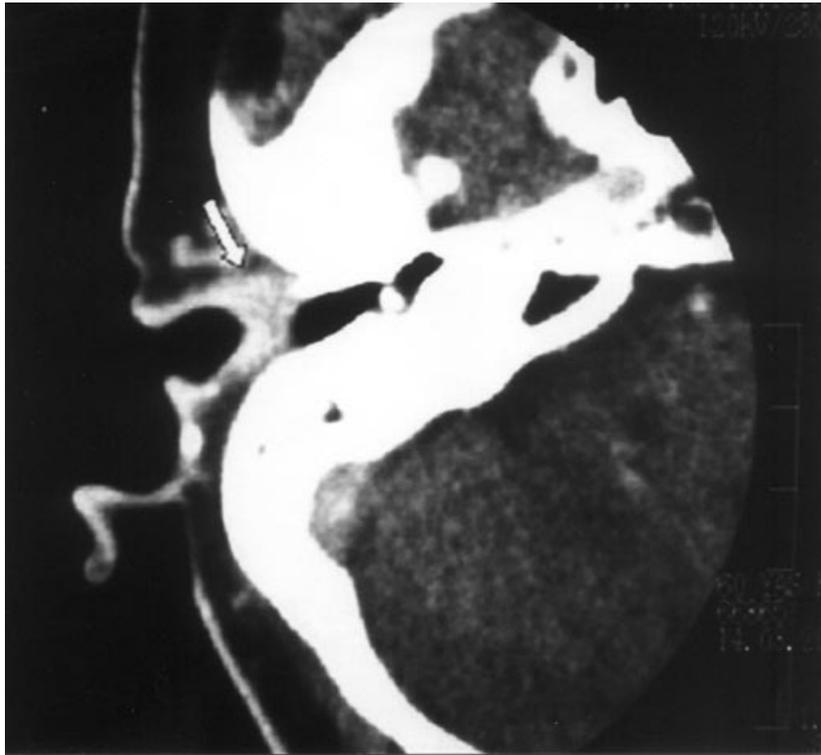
CT scan shows slight thickening and mild contrast enhancement in the soft tissue of the right external auditory canal.
